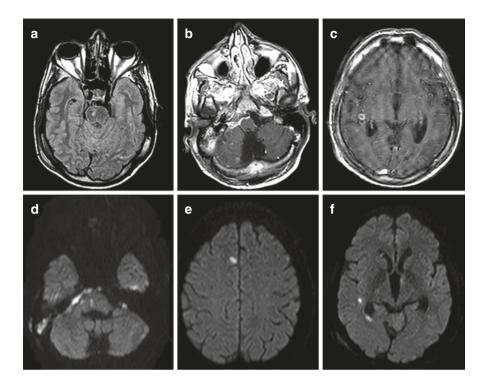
Patient with right-sided mastoiditis and multiple brain micro-abscesses. (a) Axial FLAIR image showing a right paramedian pontine abscess. (b) Post-contrast axial T1-weighted image showing right-sided mastoiditis and leptomeningeal enhancement. (c) Postcontrast axial T1-weighted image showing a ring-enhancing lesion at the supratentorial level. (d) Empyema in the right prepontine cistern showing restricted diffusion. (e, f) DWI showing central restricted diffusion within the supratentorial lesions
